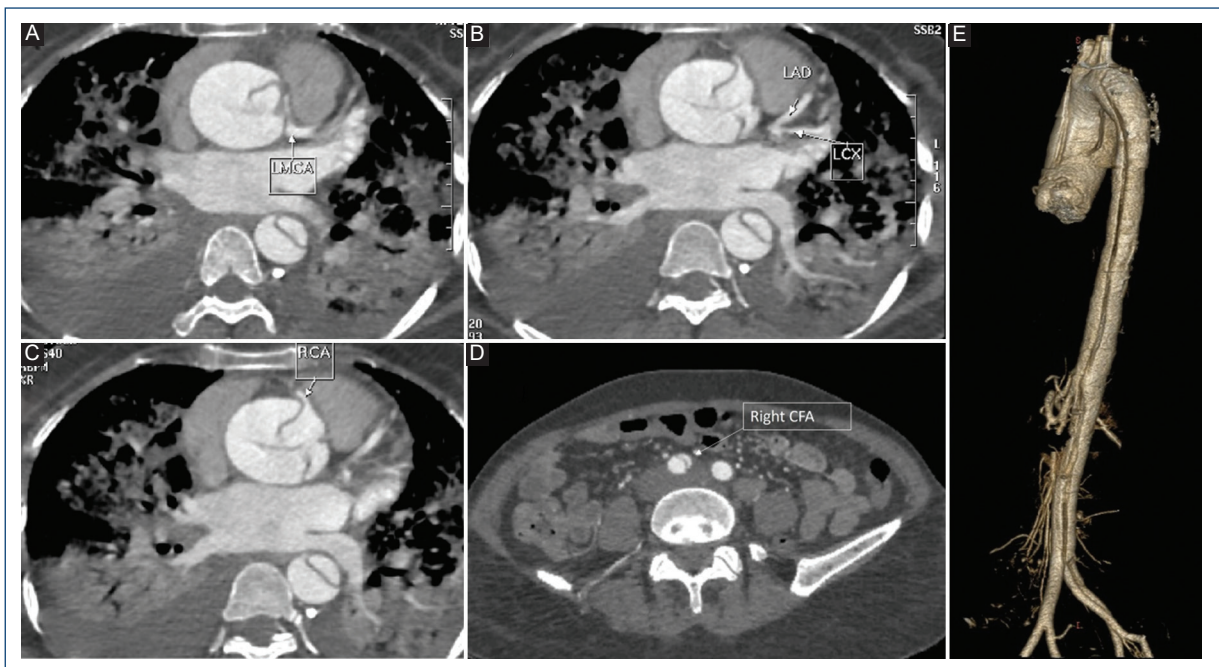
A-D: multidetector computed tomography (CT) aortogram demonstrating aortic dissection flap arising from ascending aorta, occluding the left main coronary artery and extending till the right common femoral artery. E: 3D reconstruction of the CT aortogram showing the dissection flap involving the whole length of the aorta and its extension into the right common femoral artery.
